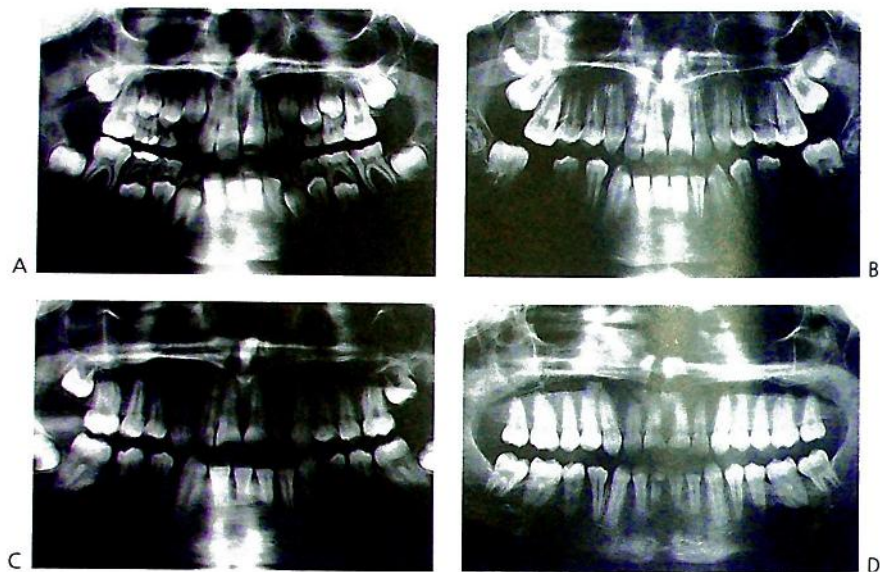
(A–D) Serial panoramic radiographs showing mesial migration of the second and third permanent molars following timed extraction of carious first permanent molars.
